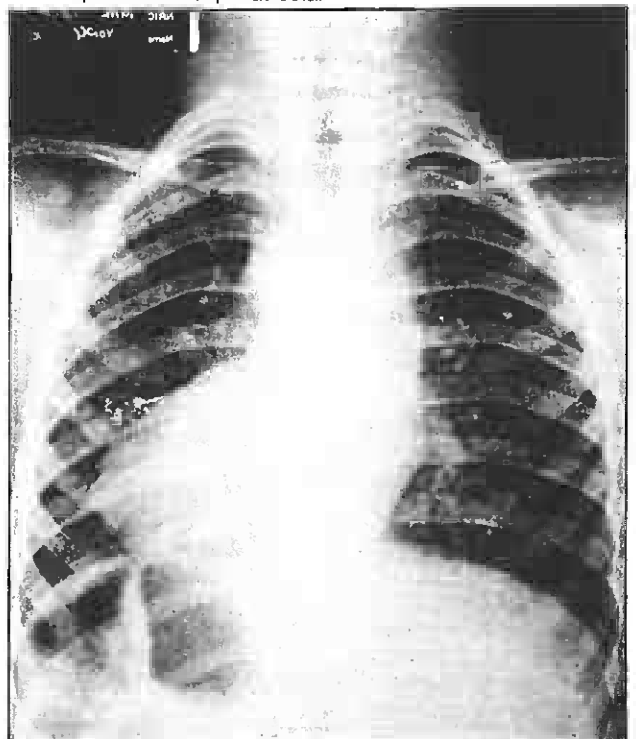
Chest roentgenogram showing heart in the right hemithorax with liver shadow situated in the left upper abdomen (dextrocardia with situs inversus).
